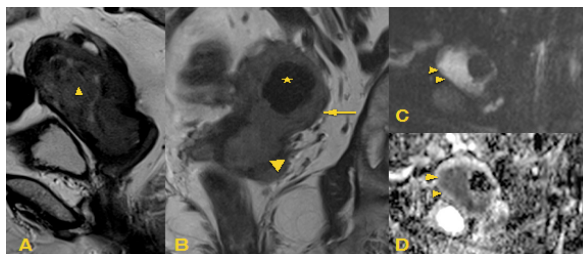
Carcinoma Endometrium stage IIIB (A) Sagittal T2W and (B) Coronal T2W images 70 year old patient showing a heterogenous and hyperintense mass in the endometrial cavity (triangle) invading full thickness of the myometrial wall (arrow) as well as extending into the cervical canal (arrowhead). A hypointense myoma(*) is seen in the posterior wall. (C) DWI and (D) ADC images show strongly restricted diffusion (double arrowhead).
